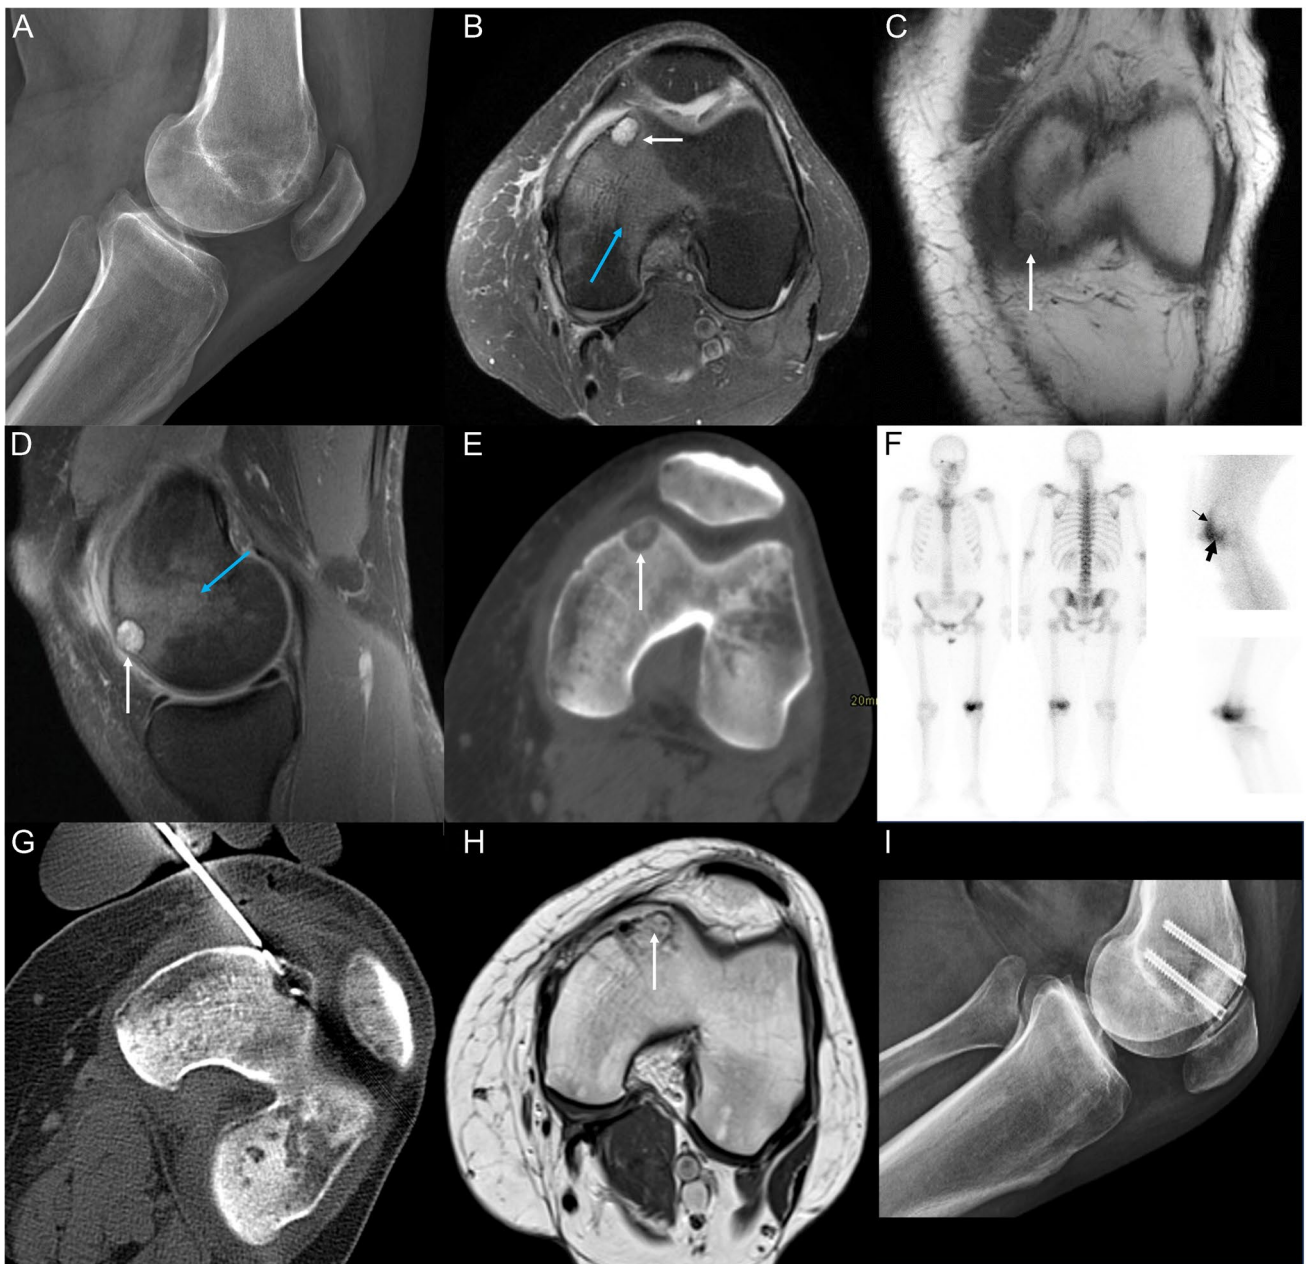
A Lateral plain film: lytic lesion with sclerotic rim in the left antero-internal femoral condyle. B Magnetic resonance image (MRI), axial T2 fat suppressed-weighted image (FS-WI): 1-cm hyperintense round lesion (white arrow) with bone marrow (BM) edema signal (blue arrow) and joint effusion. C MRI, coronal T1-WI: mild hypointense round lesion (arrow). D MRI, sagittal proton density-FS-WI: well-defined round lesion (white arrow) with BM edema signal (blue arrow). E Axial computerized tomography (CT): well-defined lytic lesion in the subchondral internal femoral condyle with punctate calcifications (arrow). F Bone scintigraphy. Whole body bone
